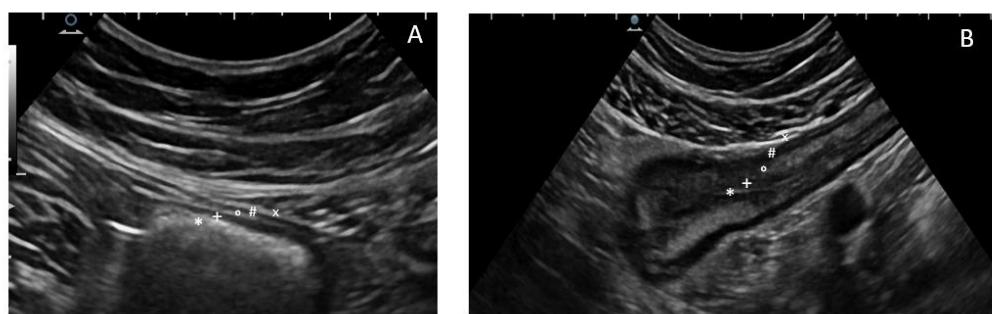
The five concentric layers of a normal (A) and thickened (B) bowel wall at ultrasonography. The most inner layer identifies the hyperechoic mucosa/lumen interface (*), then the hypoechoic mucosa (+), the hyperechoic sub-mucosa (°), and the hypoechoic muscularis propria (#), while the most outer layer is an echogenic interface between the serosa and the confining organs or structures (x).
